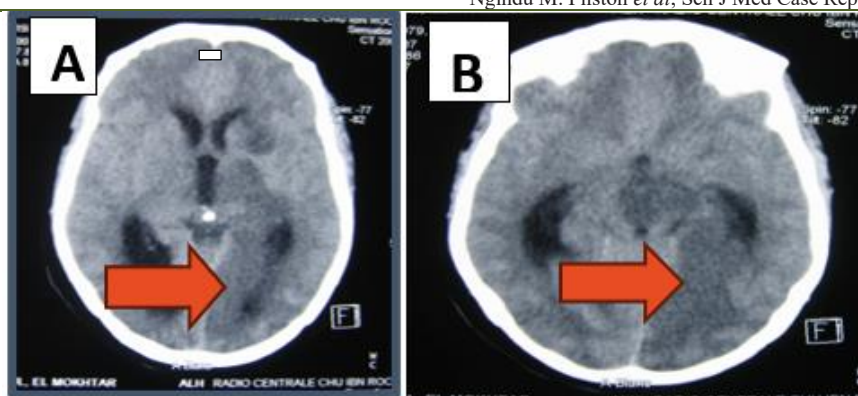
Figure A, B: Computed tomography (CT)
